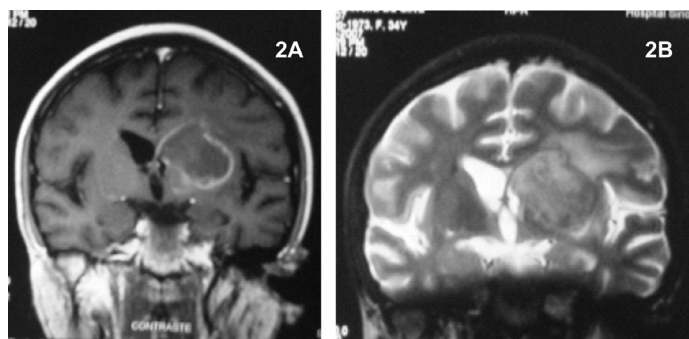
A) A magnetic resonance imaging (MRI) showed a large expansive brain lesion with intermediate signal intensity and ring enhancement on T1-weighted image after gadolinium administration. B) MRI showed intermediate signal intensity on T2-weighted image.
